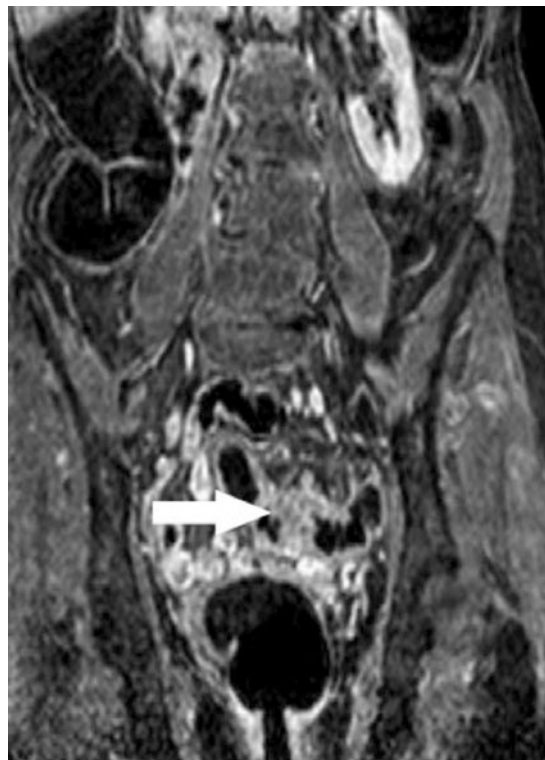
Coronal T1-weighted SPGR post IV image in a patient who had a failed colonoscopy due to inability to pass the colonoscope beyond an occluding sigmoid lesion, which proved to be benign related to diverticular disease (Courtesy of Michael Patrick Achiam, MD, Copenhagen University Hospital Herlev, Herlev, Denmark)
